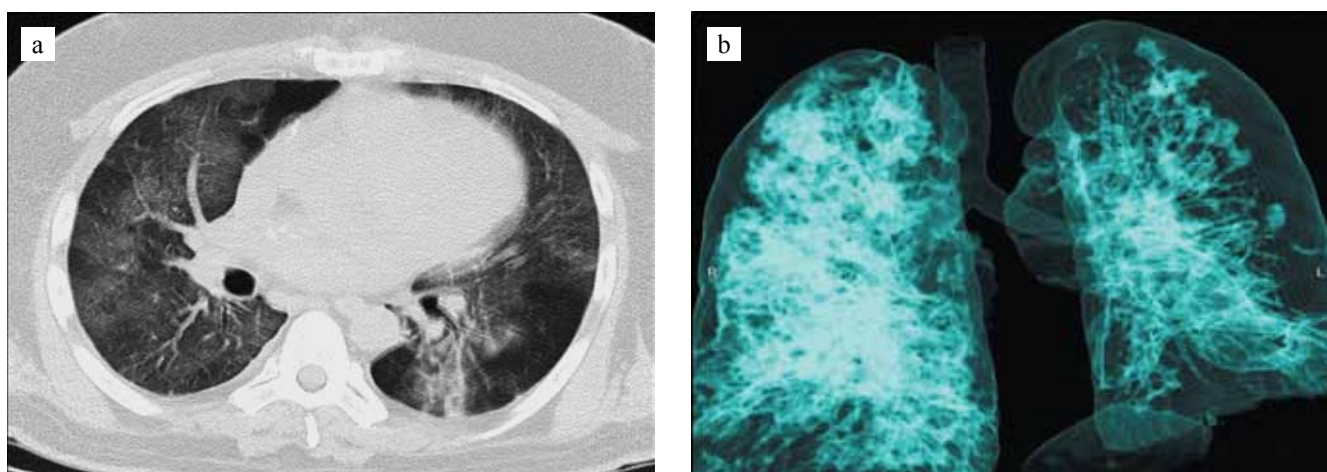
a, Axial chest CT image (18/11/20); b, Chest CT image in pulmonary view (18/11/20)
